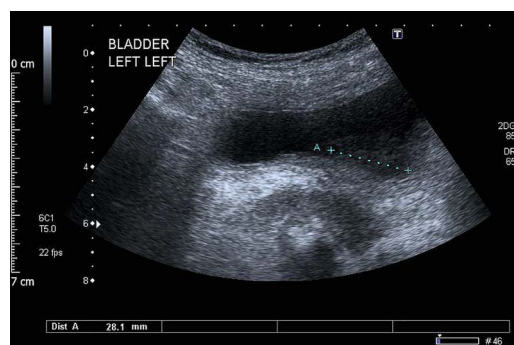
Ultrasound image demonstrating mural bladder mass.
